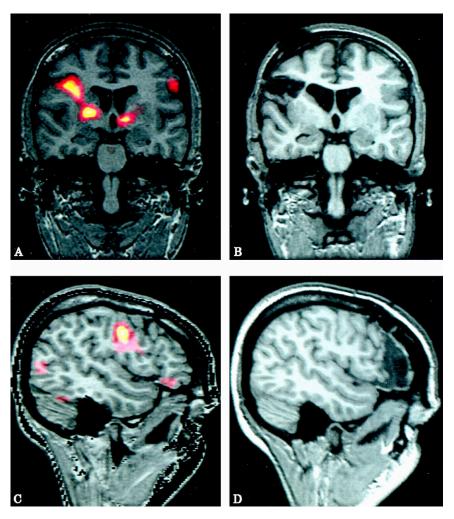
Pre-operative subtraction ictal SPECT coregistered with MRI (SISCOM) images (A and C) and post-operative coregistered MRI (B and D). A and B, complete excision of neocortical region underlying SISCOM focus. C and D, non-excision of neocortical region underlying SISCOM focus. C and D, non-excision of neocortical region underlying SISCOM focus. In the accompanying paper (O'Brien *et al.* Subtraction peri-ictal SPECT is predictive of extratemporal epilepsy surgery outcome. *Neurology* 2000; 55: 1668–1677) it was shown that resection of the SISCOM focus was significantly more likely to result in a good post-operative outcome. Copyright 2000 AAN Enterprises, Inc. Used with permission.
